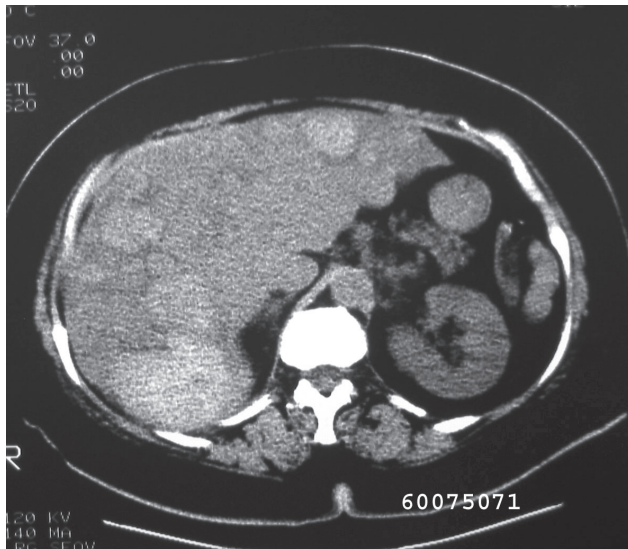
Spontaneous bleeding of metastatic liver tumors in a 59-year-old male with known carcinoid tumor of the small bowel. Plain CT shows multiple hyperdense masses of various sizes, which proved to be metastasis with bleeding.
